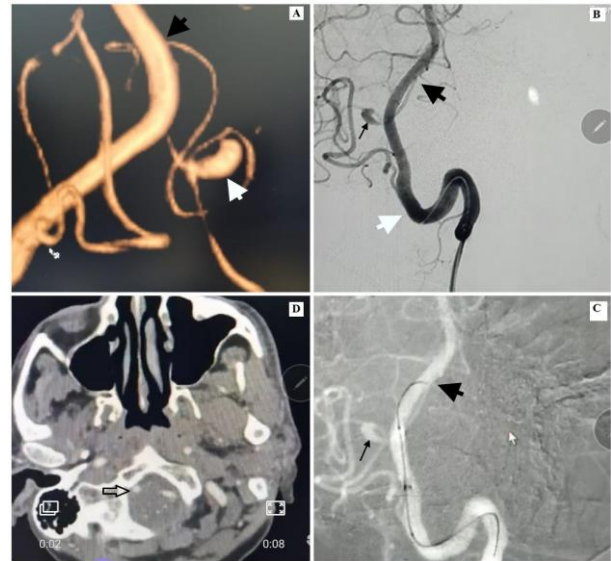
(A). clockwise: 3D(A) & DSA image(B) of Left Vertebral angiogram Showing origin of right PICA (Black arrowhead) After origin PICA was taking a U turn and crossing to opposite side. A saccular aneurysm was identified at the junction of first and second loop bifurcation.(white arrowhead) . Micro wire (Synchro-14) tip negotiating the origin of right PICA(C) (Black arrowhead) from the left vertebral artery at acute angle.CT angiography axial image (D) confirms the location of aneurysm (Arrowhead).
